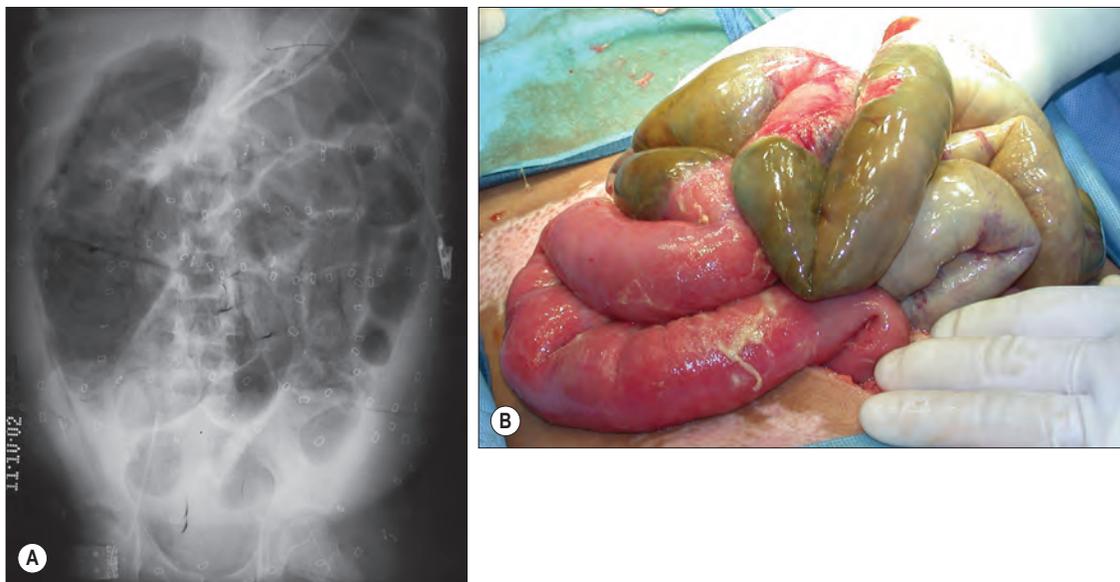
Necrotizing enterocolitis. (A) Representative radiograph demonstrating multiple, dilated, persistently “fixed” bowel loops, an ominous sign for full-thickness necrosis of involved segments of bowel. (B) At operation, multiple necrotic bowel loops were found.
